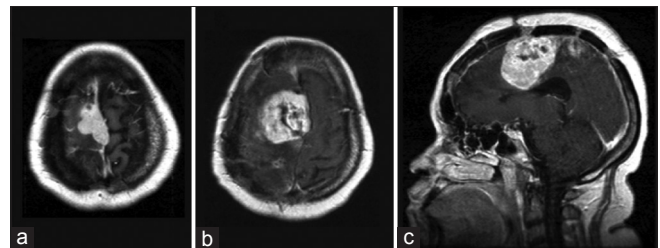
Preoperative Post contrast T1 axial (a) MRI image indicating a vertex meningioma. Post contrast T1 MRI images axial (b) and coronal (c) demonstrating large recurrent lesion 3 years after surgery at operative site
